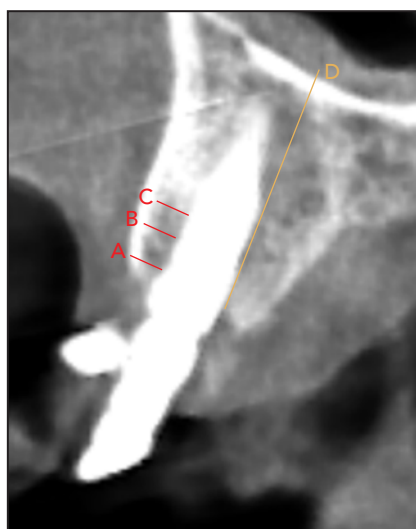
Measurements taken on CBCT images. Lines A, B, and C were drawn on the buccal bone plate at the platform level and 2 and 4 mm apical of the implant, respectively. Line D was used to determine bone plate height.
